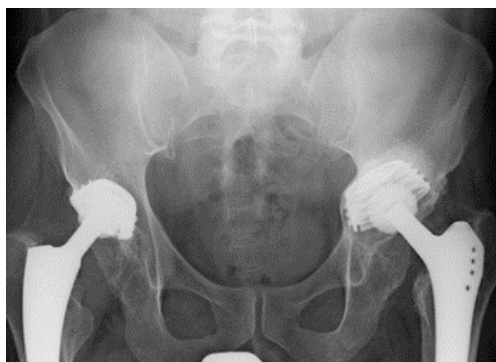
Anteroposterior radiograph of the pelvis, showing cranial migration and loosening of the cup.
